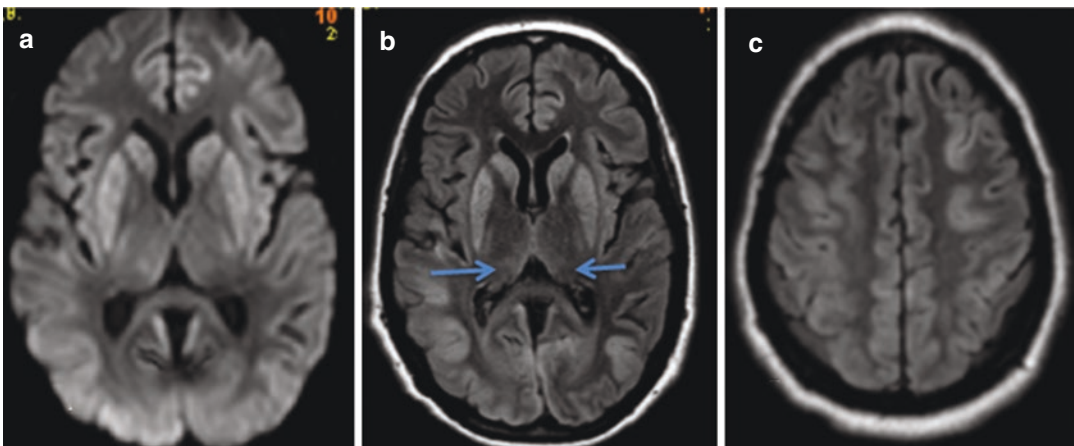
MRI 6 weeks after a 30-year-old woman presented with hypoglycemic coma. There is profound vasogenic edema of the basal ganglia (a, b) and the cortex (c), and the thalami are spared (b: arrows)
